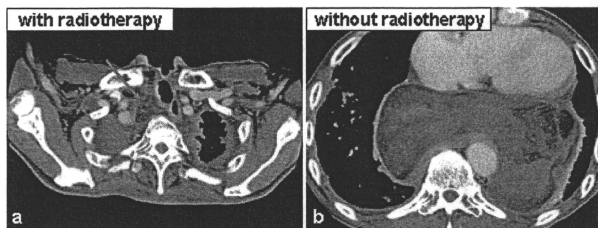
CT findings 2 months before death. The part of the tumor receiving radiotherapy (ar-row) (a) and the part that did not receive radiotherapy (b).
